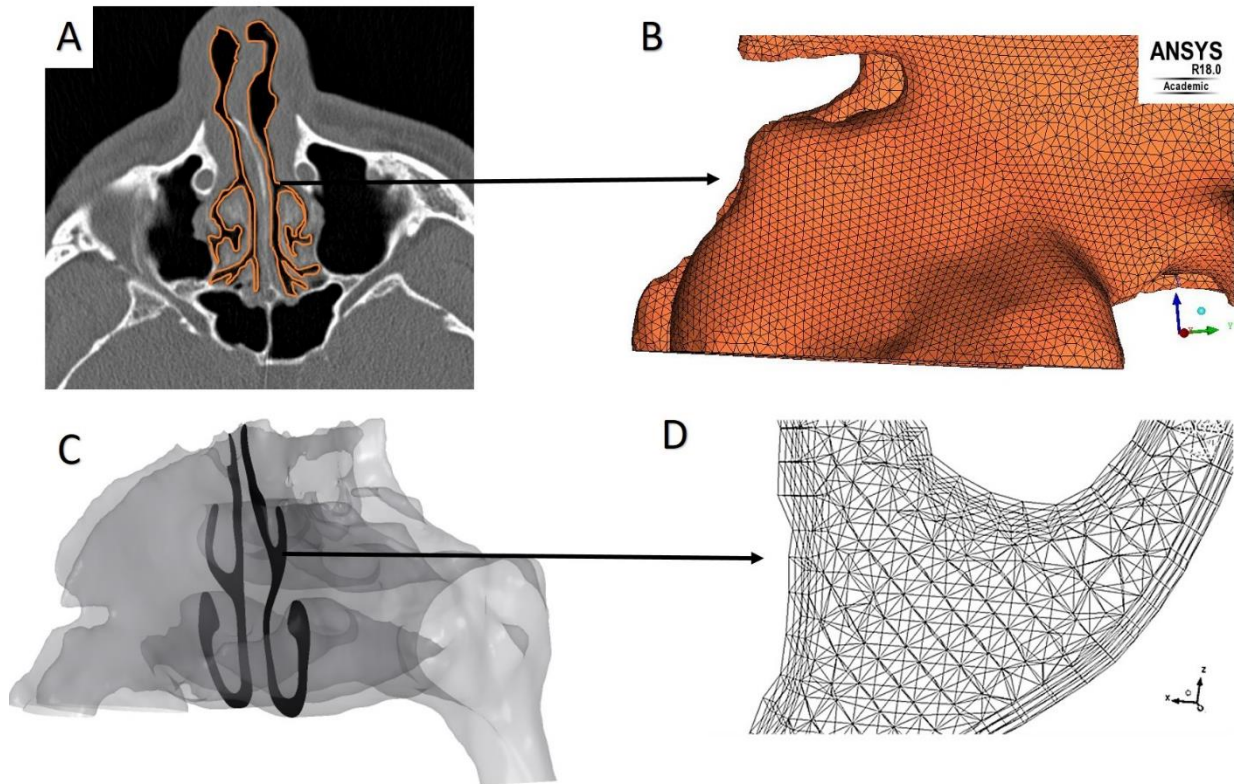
Reconstruction of human nasal cavities in-silico. (A) Segmentation of nasal airways in a CT-scan image (B) reconstruction of surface and generation of surface mesh (C) reconstructed nasal cavity model showing complex airways and (D) volume mesh generated in the airways and a three-layer prism mesh at the borders.
